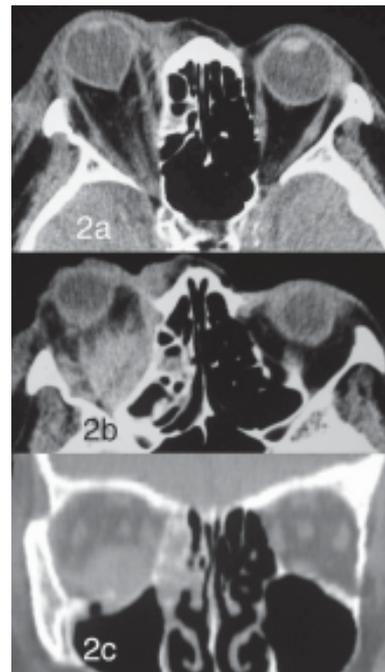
2a – Axial computed tomographic (CT) scans showing marked proptosis, with tenting of the globe by the stretched optic nerve; and 2b – right orbital haematoma with proptosis and fracture of the medial wall. A normal optic nerve canal is seen (2a). 2c – Coronal view of CT scan demonstrating medial and inferior wall fractures and orbital haematoma.
